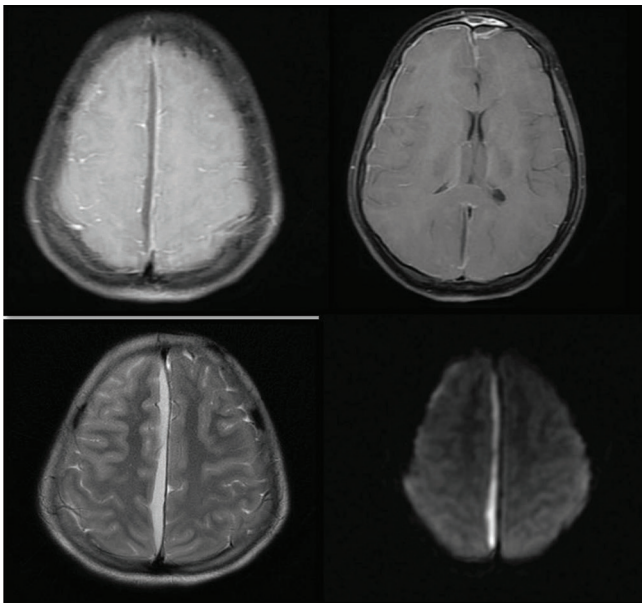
Axial T1C+/T2/DWI: showing an extra axial collection along falx cerebri on right side with mild shaggy peripheral enhancement and restriction on DWI. Thin extra axial collection showing similar enhancement characteristic is noted along left cerebral convexity. Subdural empyema in right parafalcine region and left epidural empyema along cerebral convexity in case of pyogenic CNSI
